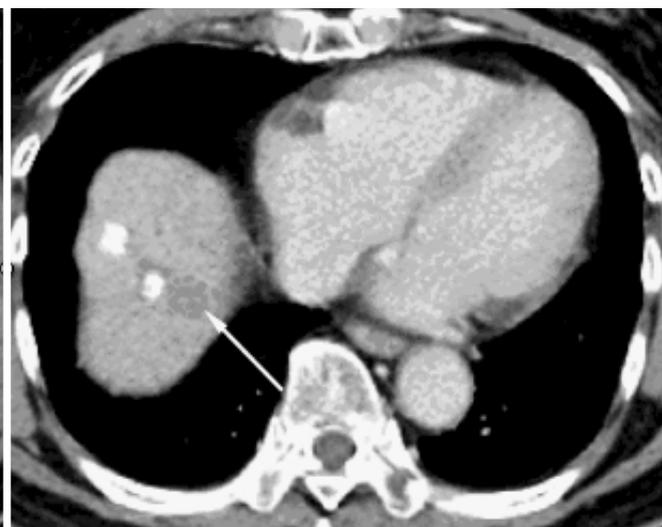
Contrast enhanced CT scan of early arterial (A) and portal phase (B) show viable HCC nodule at the right lobe dome area (segment 8).
